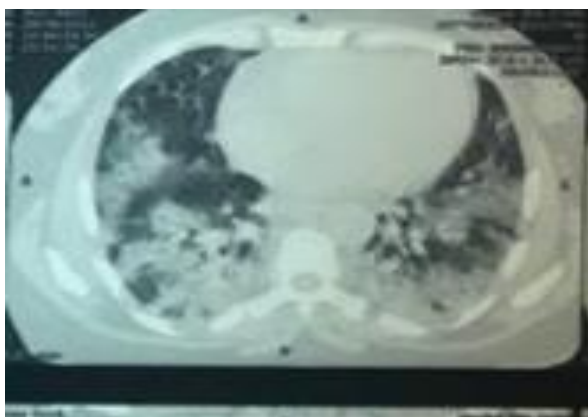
Thoracic CT scan in favor of a severe pulmonary infection of a viral infectious origin
